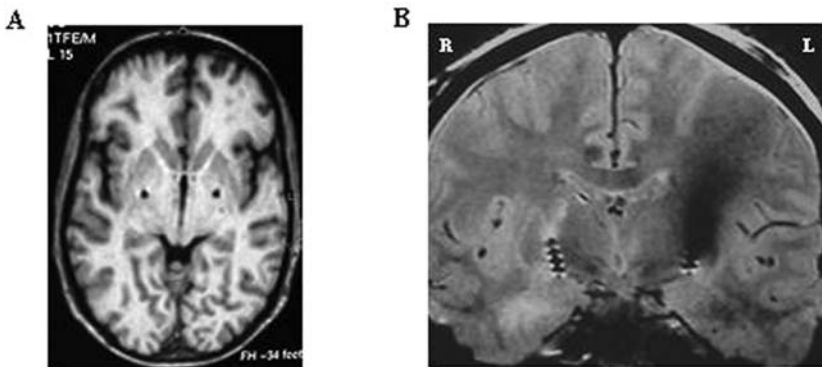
Brain MRI, T1 sequences showing the final location of the electrodes within the GPi in a patient operated for tardive dyskinesia. A: axial view; B: coronal view.
